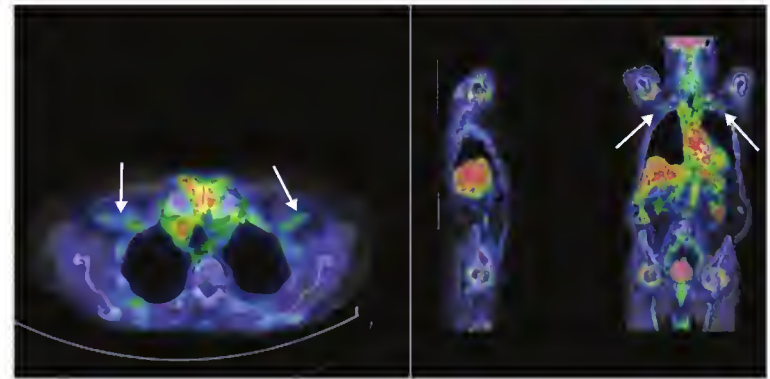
^{18}F -fluorodeoxyglucose positron emission tomographic/computed tomographic fusion images of a patient referred for fever of unknown origin. Bilateral shoulder and hip hypermetabolism is highlighted, consistent with a diagnosis of polymyalgia rheumatica. Note the hypermetabolism of the subclavian arteries (arrows).
